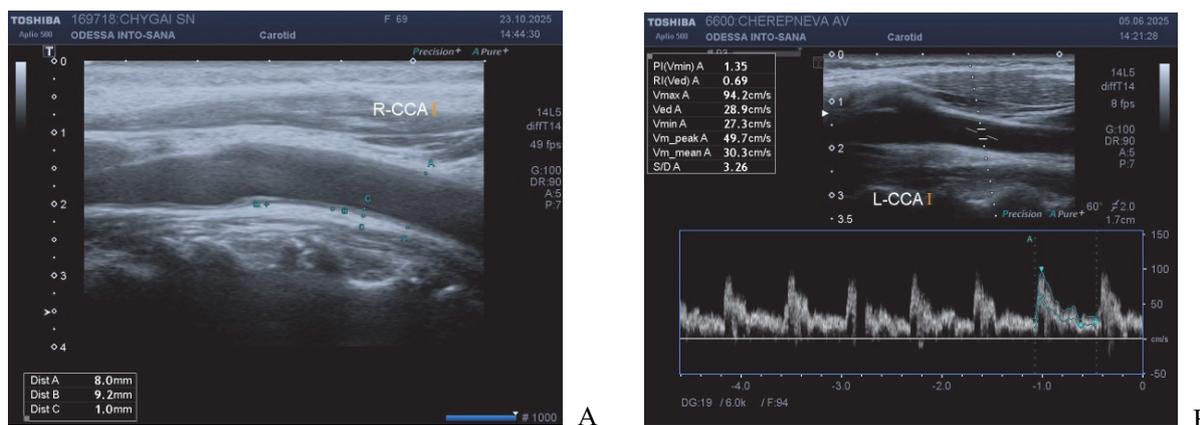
Ultrasonographic images of the common carotid artery. A – Measurement of the diameter and intima-media thickness of the carotid artery in B mode; B – Measurement of blood flow velocity in the CCA.
